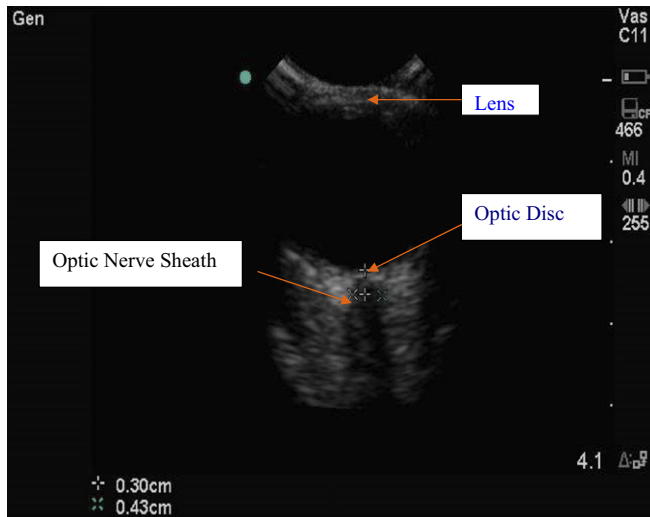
Ultrasonographic image of optic nerve sheath. The 2 “x” marks represent the point at which the diameter of the optic nerve sheath was measured.
